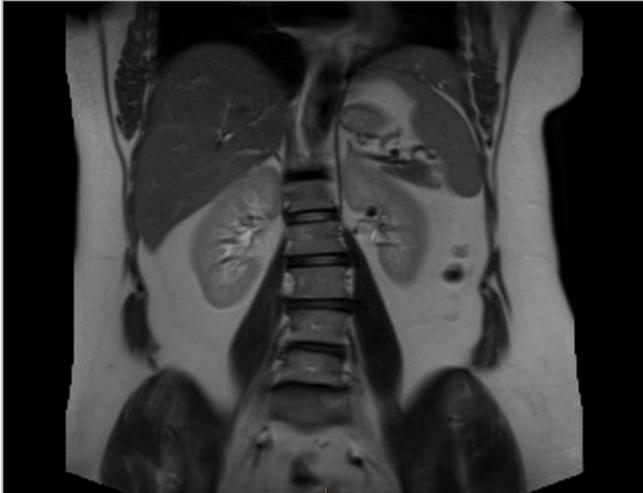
MRI coronal T2-weighted image without contrast administration demonstrating normal-appearing adrenal glands.
